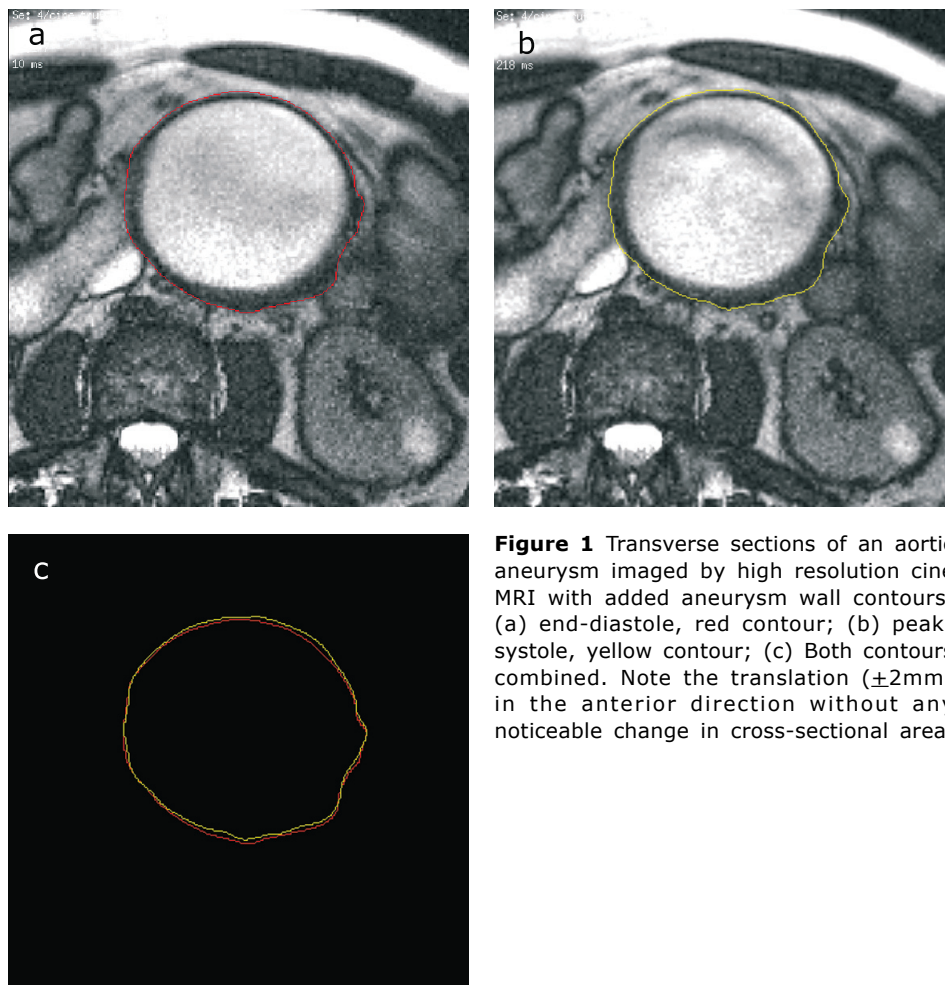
Transverse sections of an aortic aneurysm imaged by high resolution cine MRI with added aneurysm wall contours. (a) end-diastole, red contour; (b) peak-systole, yellow contour; (c) Both contours combined. Note the translation ($\pm 2\text{mm}$) in the anterior direction without any noticeable change in cross-sectional area.
